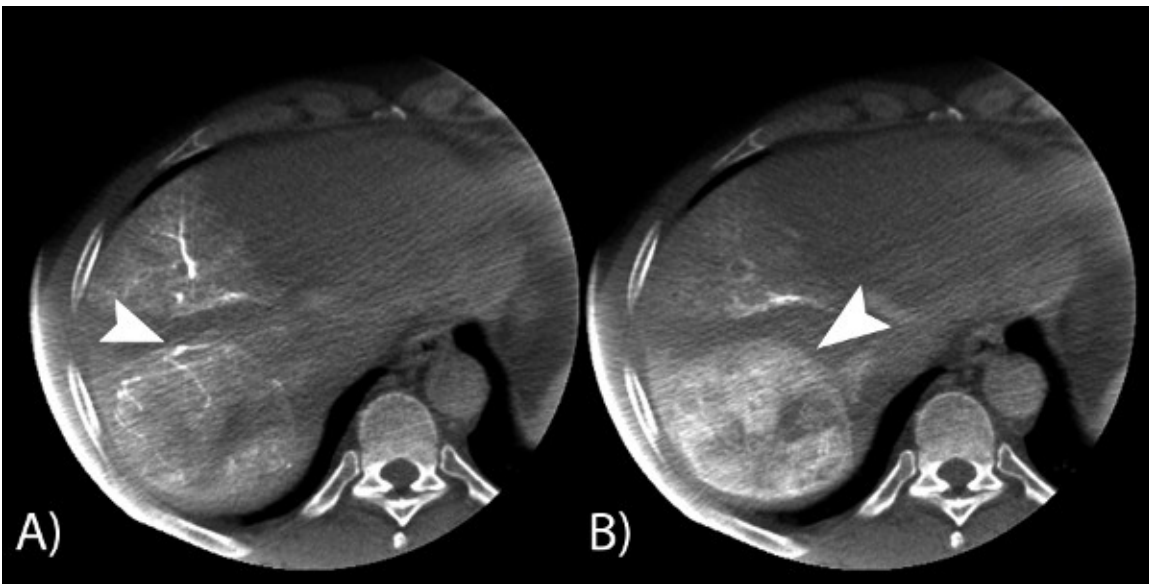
Representative axial images of two phases of one DP-CBCT obtained intraprocedurally, before the embolization. (A) represents the arterial phase and image (B) depicts the venous phase. The first phase shows opacification of the arterial tree of the liver and feeding arteries of the single hepatocellular carcinoma (white arrow) and the second phase shows liver tumor margins (white arrow).
